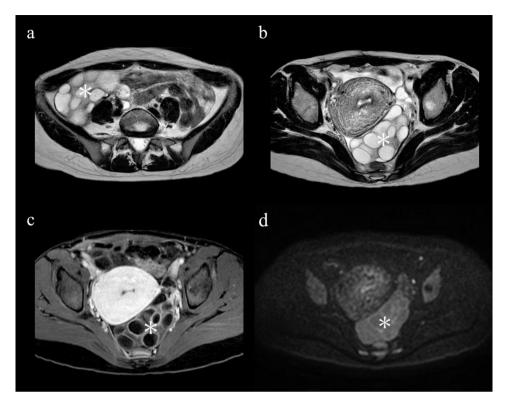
On T2-weighted images (spin echo; repetition time [TR]/echo time [TE], 4500/100 ms), the right ovary was swollen to 9.2 cm (a: *) and the left ovary to 8.7 cm (b: *) in maximum diameter. Both were accompanied by multiple large follicle-like cysts. The uterine wall showed edematous thickening. Cyst walls were uniformly enhanced on contrast-enhanced fat-suppressed T1-weighted images (gradient echo; TR/TE, 5.8/1.86 ms) (c: *), and no solid component was observed in the cysts. No abnormal diffusion restriction was observed in masses in either ovary on diffusion-weighted image (b = 1000 s/ mm², TR/TE, 4359/78 ms) (d: *)
